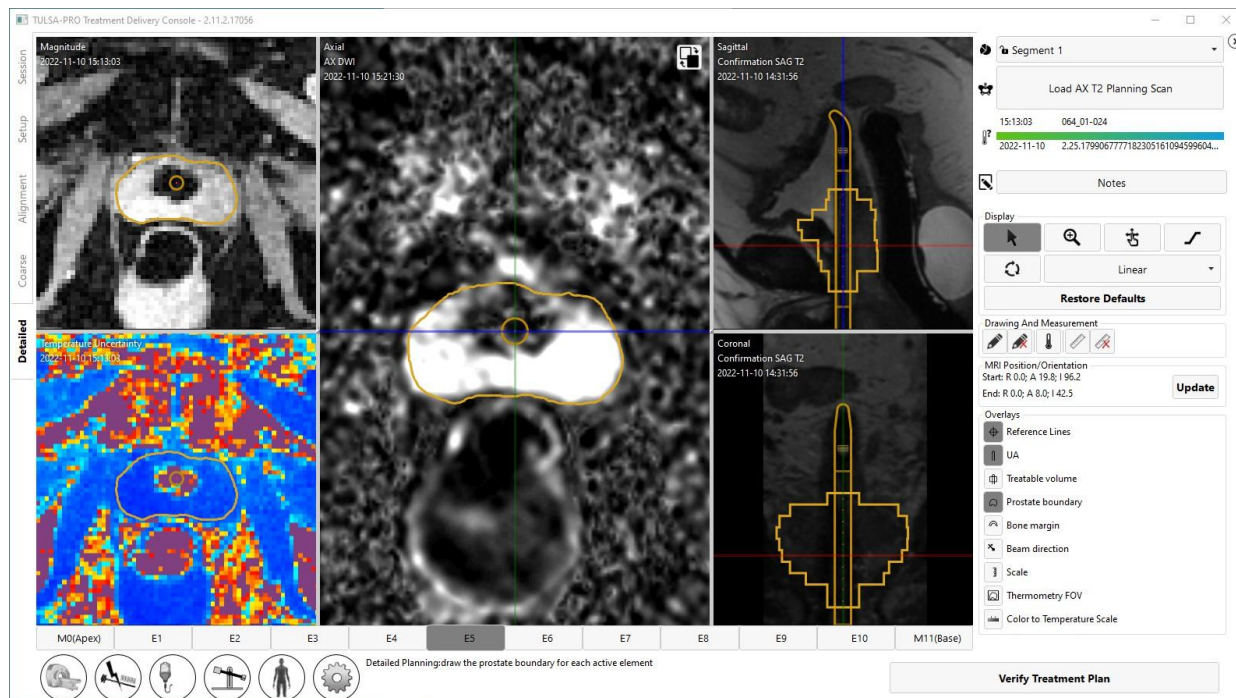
Using mpMRI vision in Detailed Planning to visualize intraprostatic differences in tissue properties on an AX DWI scan and select tissue intended for ablation
